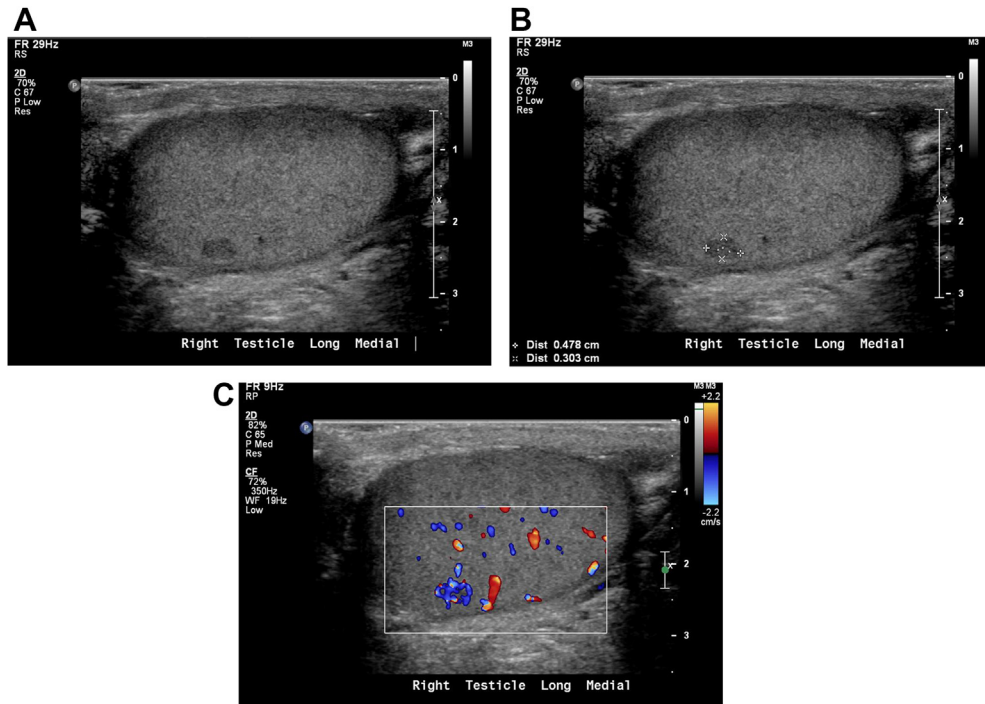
Testicular hemangioma in a 34-year-old man. (A and B) Sagittal grayscale ultrasound images of the right testicle show a hypoechoic intratesticular mass located within the posterior superior pole, measuring 5 × 3 mm. (C) Sagittal color Doppler ultrasound image of the right testicle demonstrates blood flow within the intratesticular mass.
